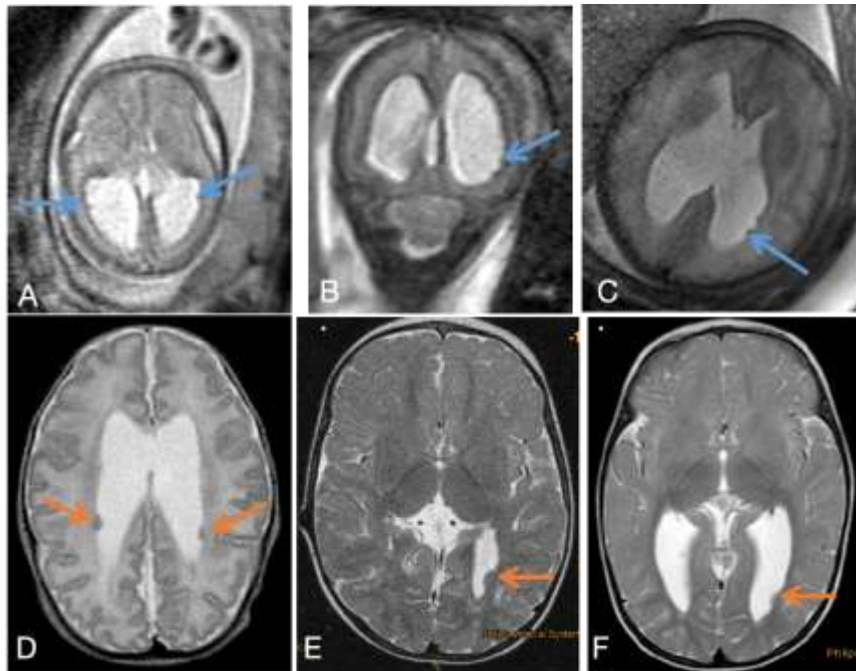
Prenatal and postnatal follow-up MRI of three CM II + heterotopia cases.
